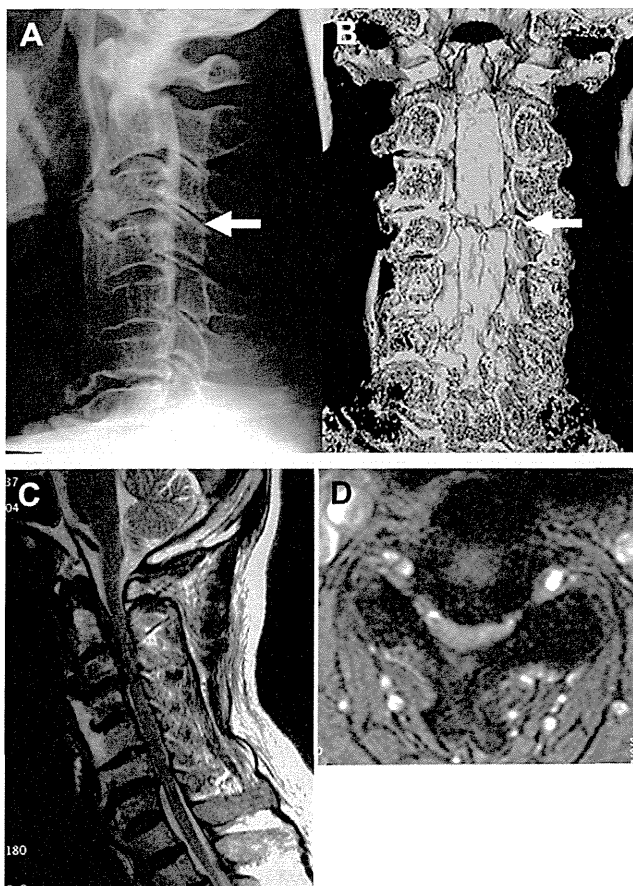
Images of the cervical spine of a 67-year-old male patient. (A) Lateral radiograph of the cervical spine. (B) Three-dimensional computed tomography prepared from the posterior view of the ossified lesions. (C) Sagittal view of T2-weighted magnetic resonance imaging (MRI). (D) Axial view of T2-weighted MRI at C3–C4. In (C) and (D), the arrows show ossification of the posterior longitudinal ligament at C3–C4.
